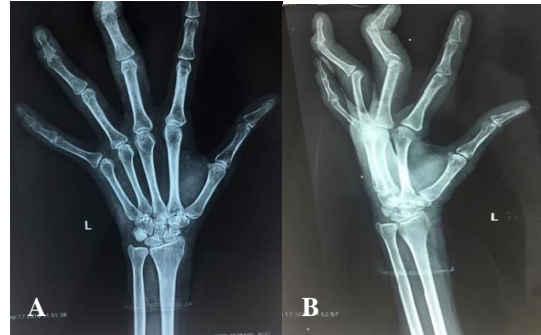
Plain X-ray of left hand; A) PA view, B) lateral view.
